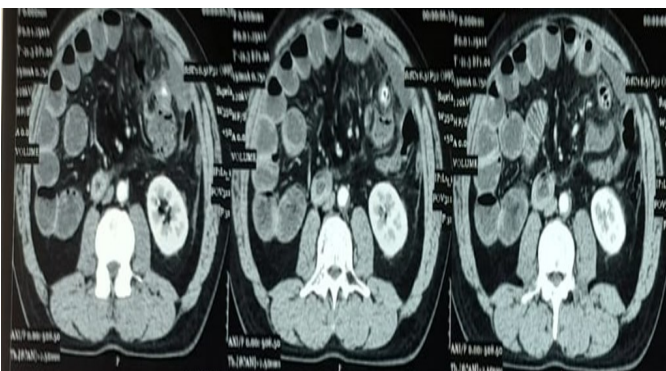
Pelvic CT scan slides showing the cecum and appendix in the left iliac fossa.
